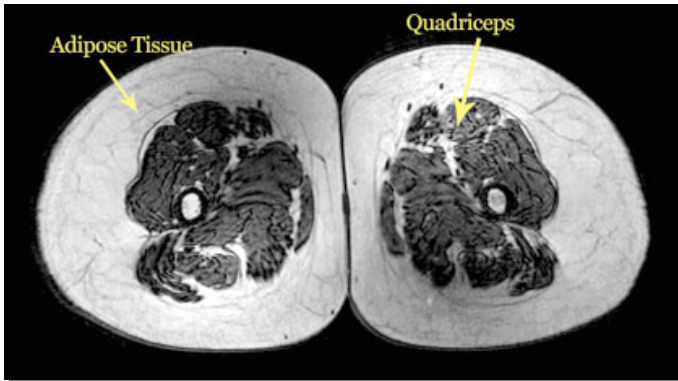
Typical Quad MRI of 40yo triathlete compared to the quad MRI of a 70yo triathlete and 74yo sedentary male. Note the significant visual difference between the SAT and IMAT of the sedentary versus masters athletes.
